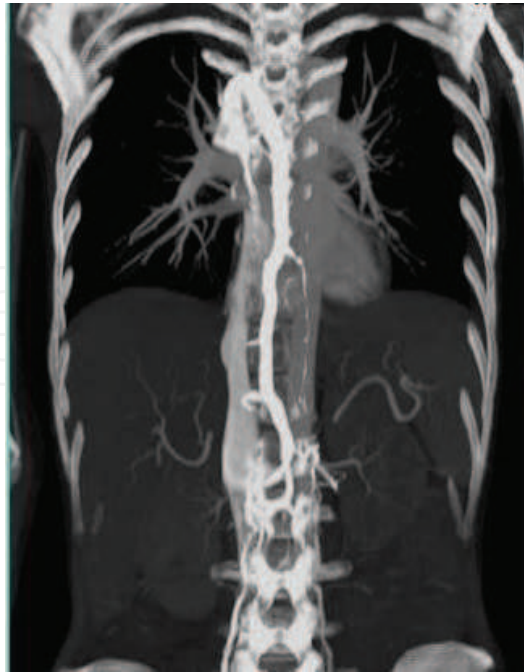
Angio-CT scan: Obstruction of the lower SVC, distal to the azygos entry point. Collateral pathways: in the azygos vein system the blood flow is inverted and venous return occurs by means of IVC.
